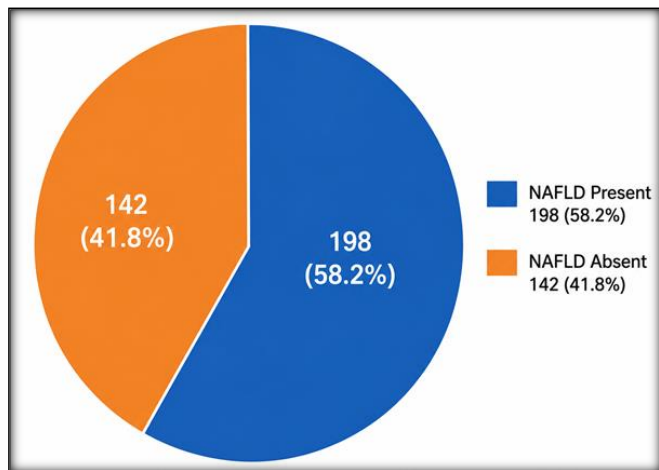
Prevalence of NAFLD among study participants as detected by ultrasonography
